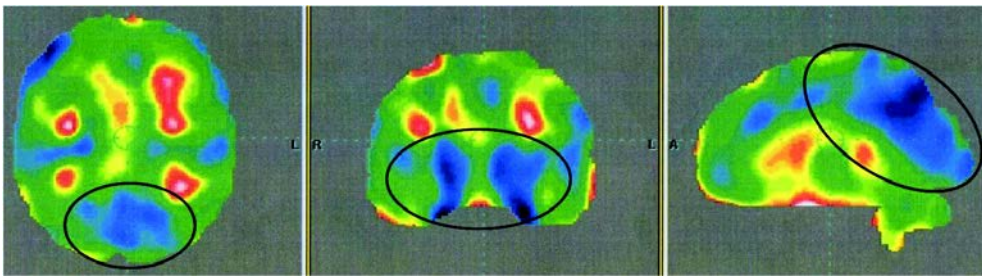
PET - CT Scan before stem cell transplantation suggestive of reduction in the metabolism of occipital lobes and mesial temporal structures bilaterally
